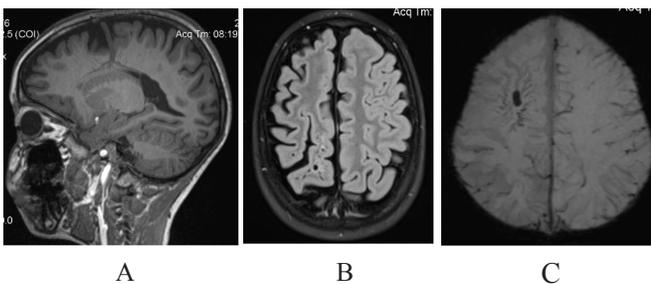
Brain MRI of a 7-year-old girl with symptomatic focal epilepsy associated with the isolated DVA.
